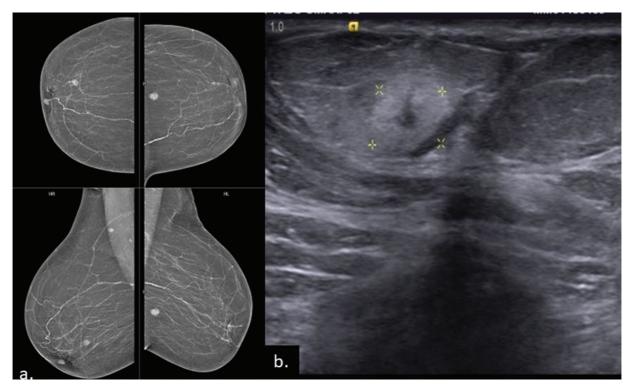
A patient with known pancreatic adenocarcinoma presented with breast lumps, which were incidentally detected on CT. (a) Mammogram reveals multiple round nodules in the outer half of the right breast and lower half of the left breast. (b) Ultrasound reveals small hypoechoic lesion with thick echogenic rim Left breast biopsy result revealed metastatic adenocarcinoma. CT, computed tomography.
